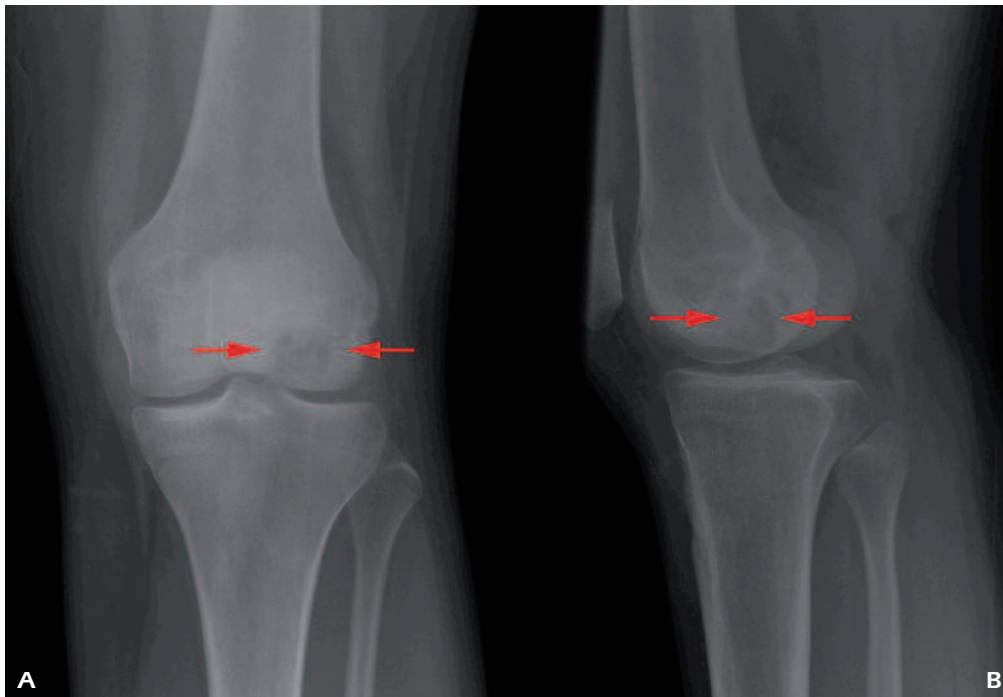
Posteroanterior (A) and lateral (B) radiographs of the knee show an osteolytic lesion of the distal femur (narrows).
